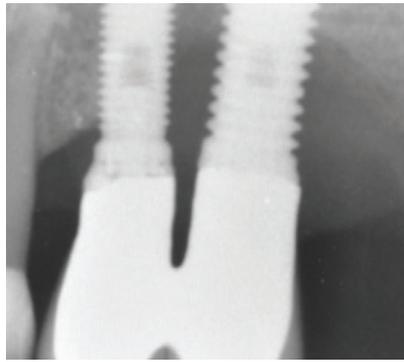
Case 2 - Baseline. The radiography shows severe peri-implant CBL.
